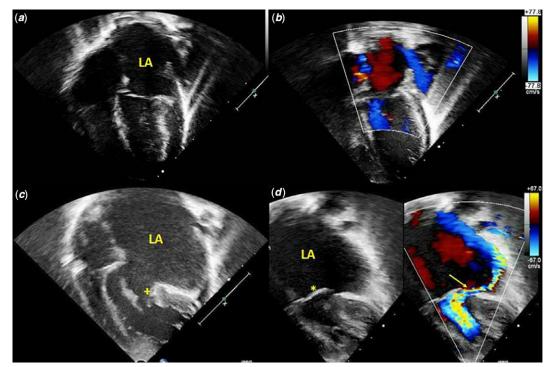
(a) Apical four-chamber view at 1 month of age shows normal size left atrium. (b) Focused color Doppler imaging shows a competent mitral valve with no regurgitation across it. (c) Apical four chamber view at 18 months of age shows massively dilated left atrium with dysplastic posterior leaflet of mitral valve (plus sign) adherent to the inferolateral wall of the left ventricle. (d) Focused color Doppler imaging shows eccentric jet of mitral regurgitation (arrow) with prolapse of the anterior leaflet of mitral valve (asterisk).
